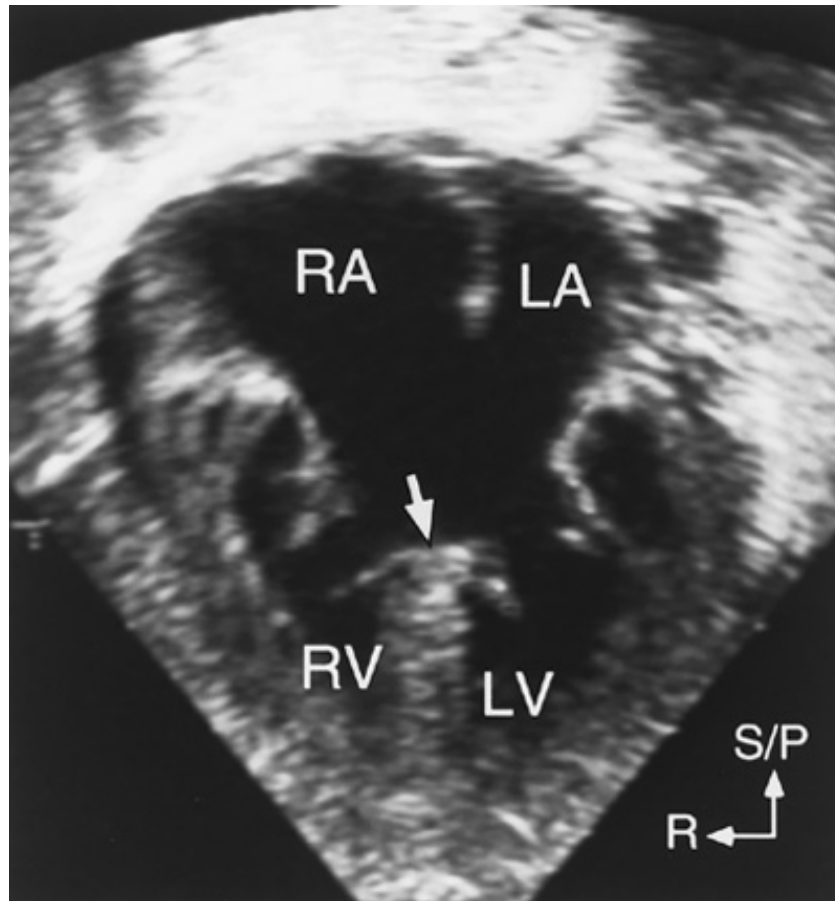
Apical four-chamber view of complete common AV canal. Note the large deficiency of both atrial and ventricular septa as well as apical displacement of the AV valves. The arrow points to the attachment of the inferior bridging leaflet to the ventricular septal crest. (From Levine J and Geva T.⁸⁵ Reproduced with permission.)
